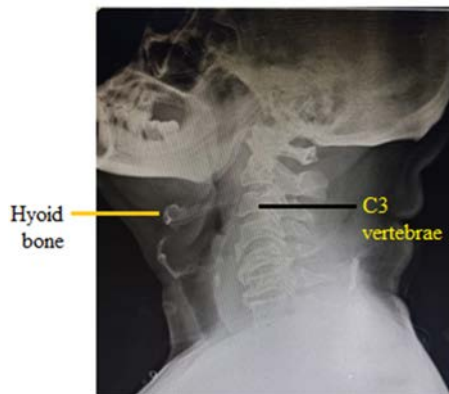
Digital Radiograph of Cervical Vertebrae (Lateral View). Hyoid Bone Compared with Cervical Vertebral Level to Evaluate the CCA Bifurcation
